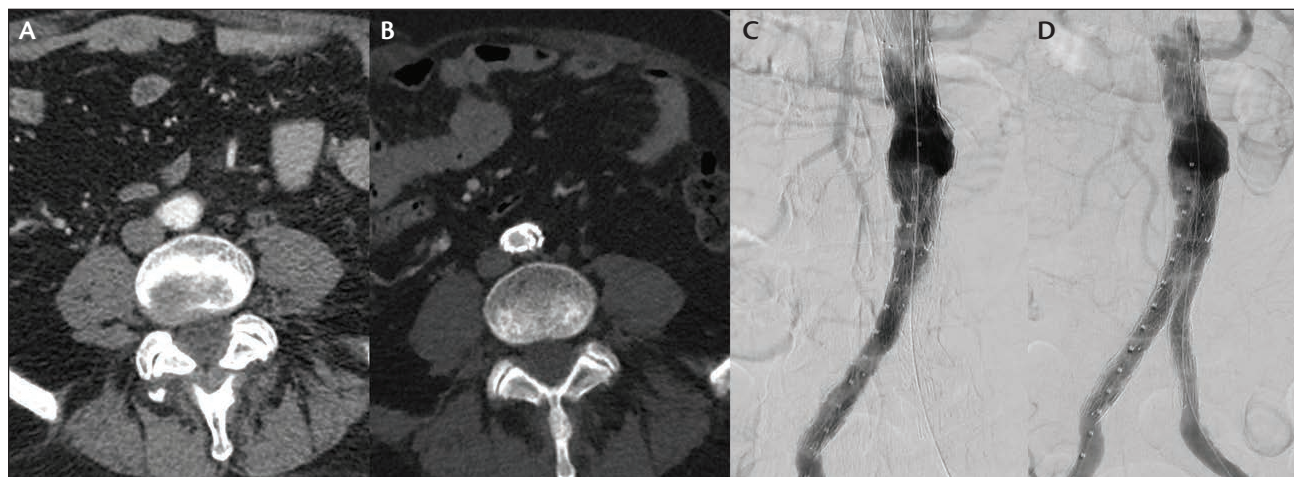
Preoperative CTA showing a narrow (18 mm) aortic bifurcation (A). CTA 4 hours postoperatively depicting acute thrombosis of a Zenith (Cook Medical) left limb due to collapse (B). Intraoperative digital subtraction angiography showing left limb thrombosis (C). Completion angiography after thrombectomy and relining of an Express left limb (Boston Scientific Corporation) (D).
